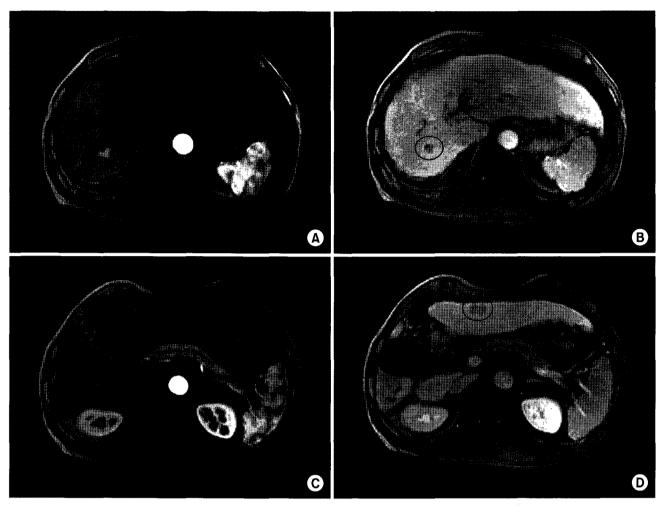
Liver MRI of 60 year-old male hepatocelluar carcinoma (HCC) patient (case 3) before hepatic irradiation. (A) There was small nodular lesion with viable HCC in segment 7. On arterial phase, the mass was enhanced (black circle). (B) There was small nodular lesion with viable HCC in segment 7. On delayed phase, the mass was showed as low signal intensity (black circle). (C) There was small nodular lesion with viable HCC in segment 3. On arterial phase, the mass was slightly enhanced (black circle). (D) There was small nodular lesion with viable HCC in segment 3. On delayed phase, the mass showed low signal intensity (black circle).
